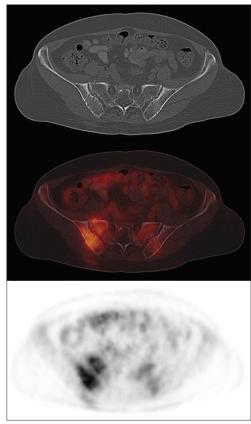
FDG PET-CT transaxial images showing moderate hypermetabolic activity in the posterior pelvis bone and soft tissue with linear needle tracts on CT
